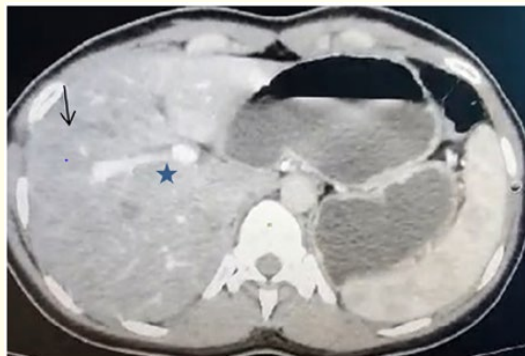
CT scan show a hepatic perfusion abnormalities (arrow) with partial thrombosis with pylephlebitis (asterisk).
